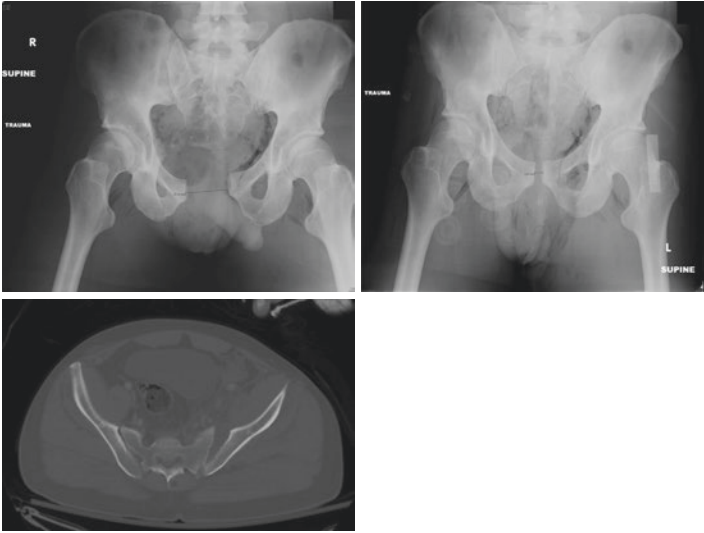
AP pelvis radiographs of a male patient with an anterior compression grade 3 injury before and after application of a pelvic binder and a representative CT image of the same patient
